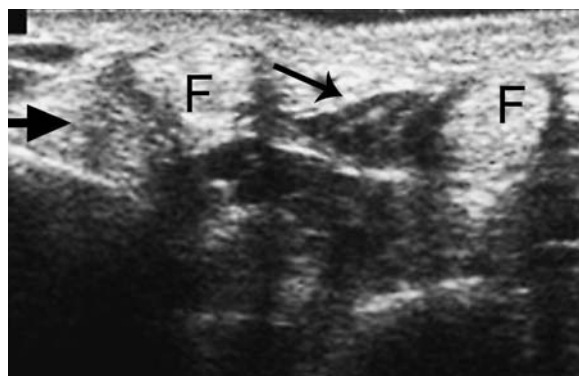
Lumbrical tear. Transverse ultrasound image. Normal flexor tendons are seen (F). Normal hypoechoic lumbrical (thin arrow) is seen, as well as hyperechoic lumbrical (thick arrow) corresponding to recent tear
